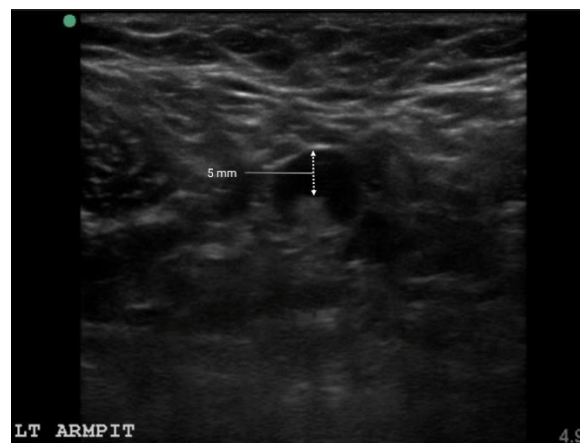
Case 2. Diagnostic ultrasound assessment of the left axillary region revealing an anechoic thickened cortex ring measuring 5 mm around the hyperechoic hilum.
